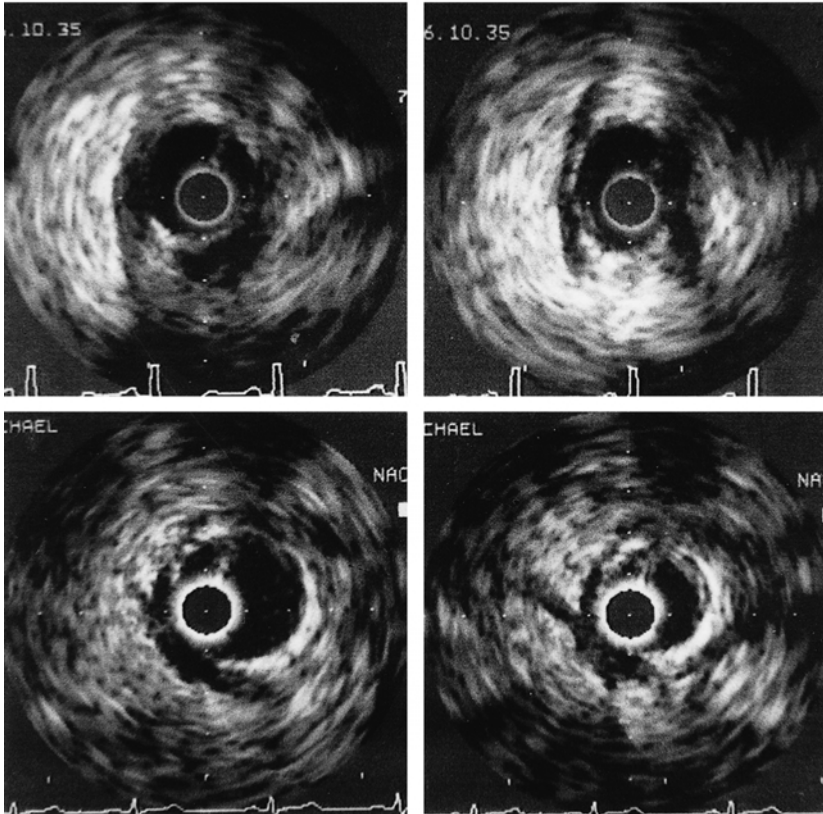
Intravascular ultrasound imaging of the myocardial bridging during diastole (left) and systole (right). A 'half-moon' like, echolucent area surrounding the bridge is seen during the whole cardiac cycle. The distance between two calibration marks is 1 mm.
